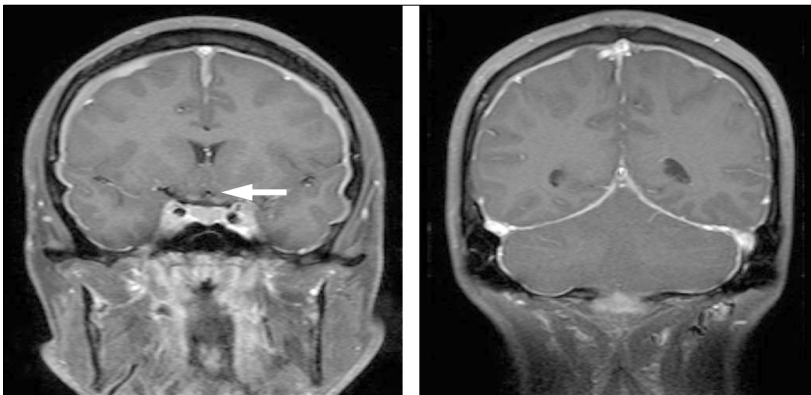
Coronal T1-weighted brain MRI of a patient with spontaneous intracranial hypotension
